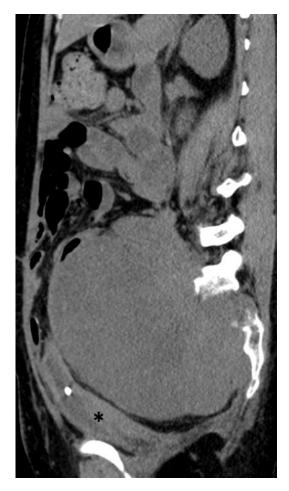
Reconstructed image in sagittal plane of CT scanidentifies a huge tumor with a clear and smooth boundary has occupies the entire pelvic cavity two months after surgery. The tumor displays substantially homogeneous density. The intestine within the pelvis is migrated towards the middle abdomen. Bladder (*) and uterine become flat under compression
